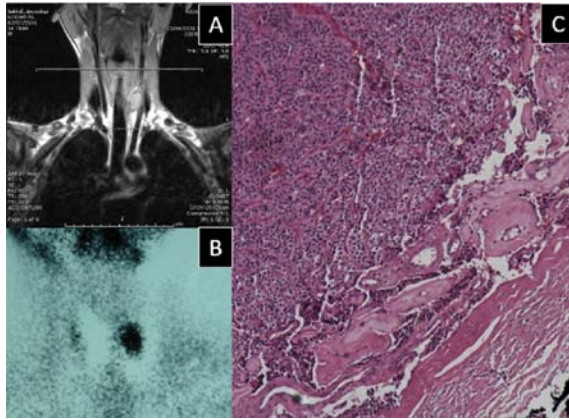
A) Magnetic resonance imaging (T1W) showing hypersignal homogenous enhancement in left thyroid lobe. B) Sestamibi parathyroid scan showing increased uptake in left thyroid lobe. C) Parathyroid mass in left thyroid lobe showing parathyroid carcinoma with capsular invasion.
